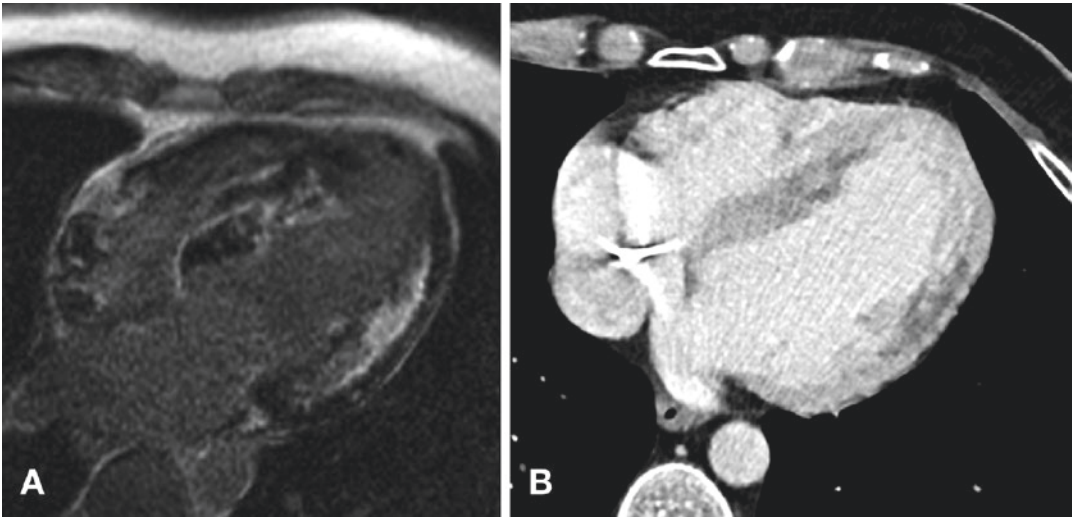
(a) Delayed enhancement in a patient with nonischemic cardiomyopathy. Four-chamber MRI delayed enhancement post-contrast sequence demonstrates increased signal from gadolinium contrast deposition into scarred myocardium. This particular sequence suppresses (nulls) the signal of normal myocardium, which appears near black. This patchy distribution not following coronary artery vascular territories suggests an infectious or inflammatory etiology rather than sequela of infarcts from coronary atherosclerotic disease. (b)
